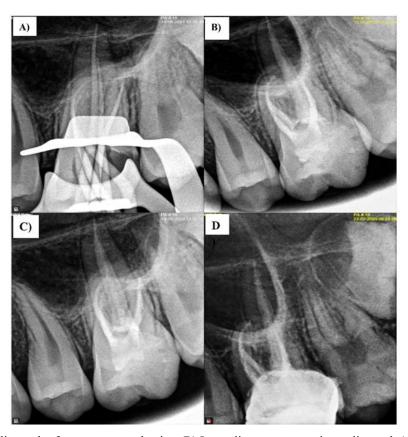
A) Radiograph of master cone selection, B) Immediate post operative radiograph (distal angulation), C) straight angulation, D) radiograph taken during the 9<sup>th</sup> month recall.
